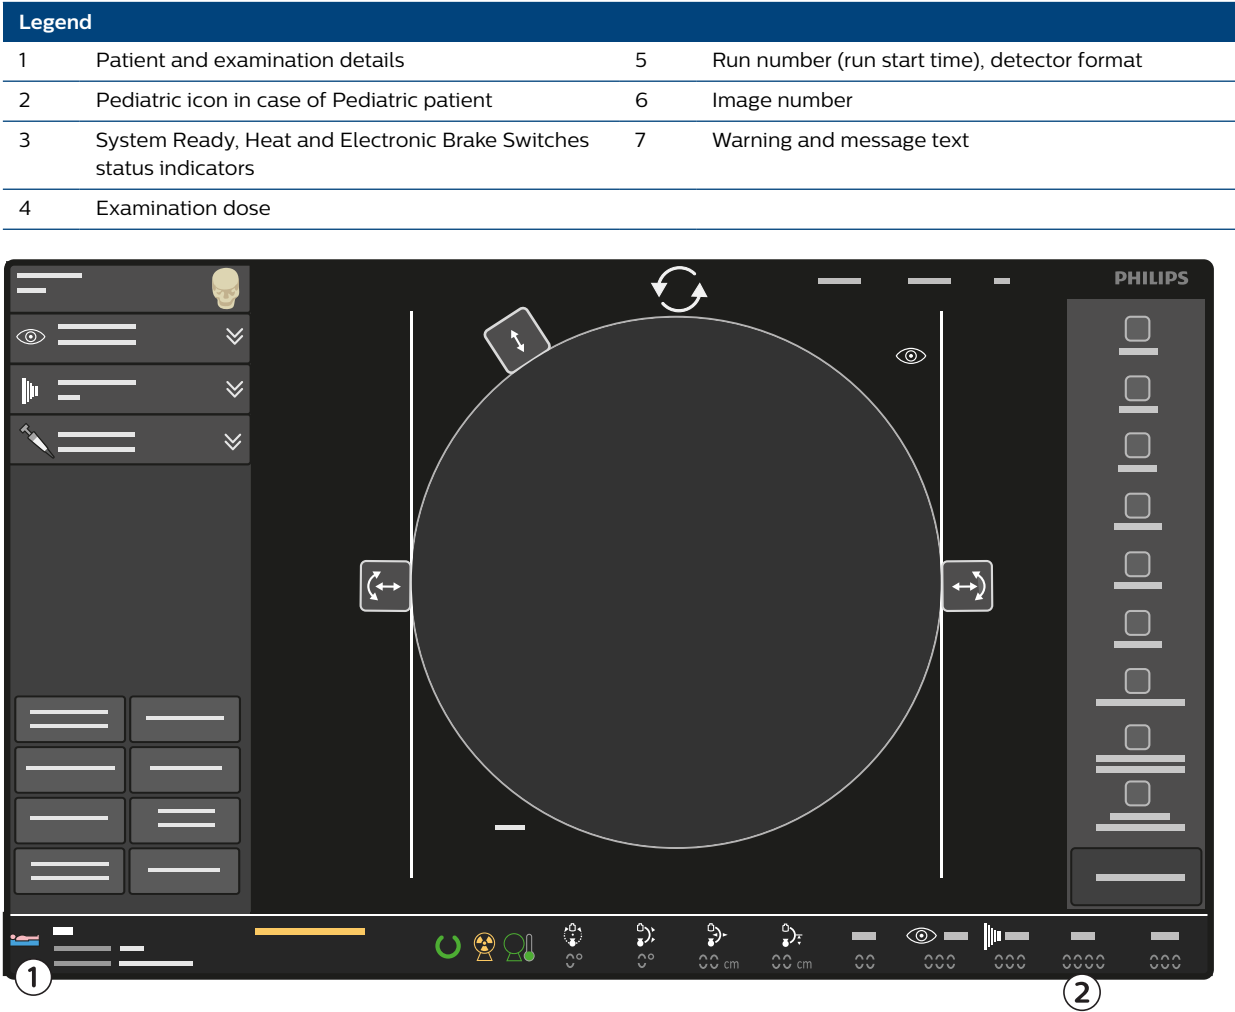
Single image screen - Live X-ray - C-arm stand
